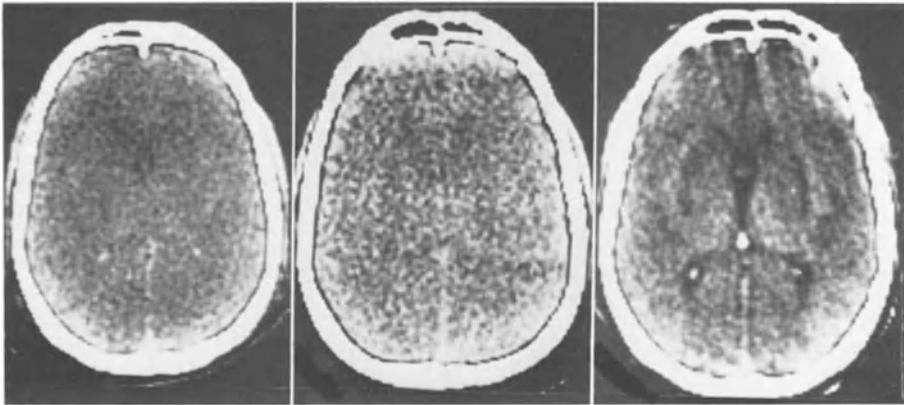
This 7 year-old boy involved in a traffic accident scored 6 points on admission to our unit. The initial CT scan showed generalized brain swelling (left). Despite hyperventilation ICP remained above 25 mmHg and the patient showed further neurological deterioration (score = 4); a further CT scan revealed a complete collapse of the ventricles and cisterns (middle). Mannitol and barbiturates controlled raised ICP and the patient made a good recovery. A further CT scan ten days after trauma showed slightly enlarged ventricles and cisterns (right)
